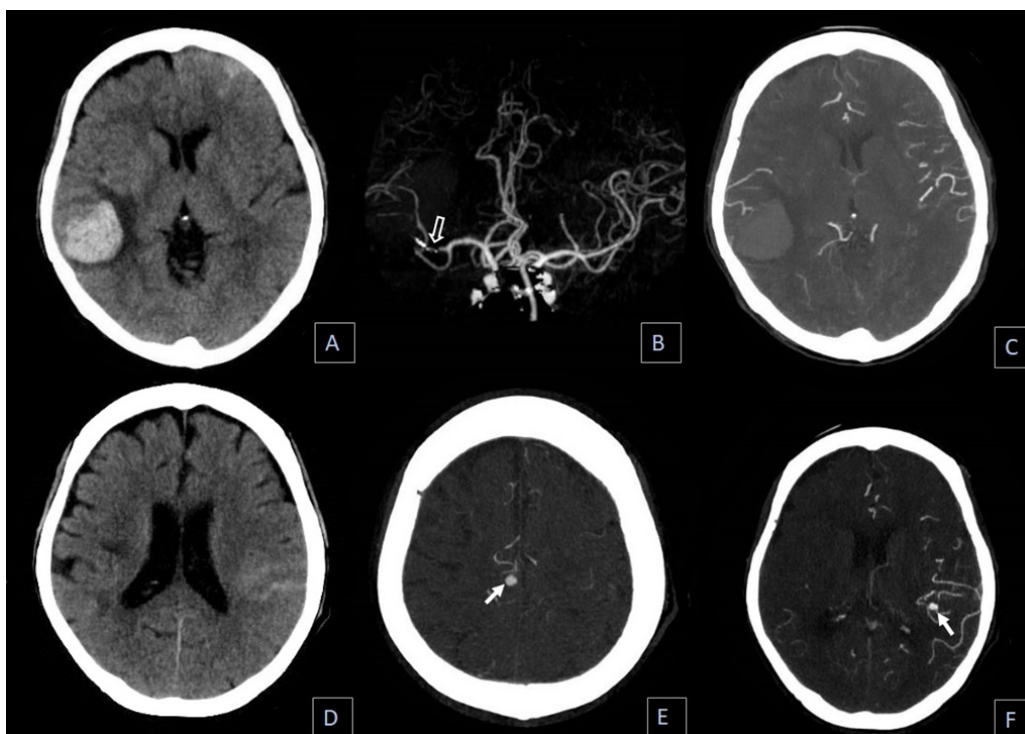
A 51-year-old female underlying SLE and AIHA, post aortic valve replacement, and LV-RA fistula repair, developed candida septicemia and infective endocarditis of the prosthetic heart valve. Axial CT brain (A) reveals acute intraparenchymal hematoma in the right temporal lobe and acute subarachnoid hemorrhage in the left frontal sulci. 3D MIP (B) and axial MIP CT angiography (C) show severe stenosis of the proximal M2 segment of right MCA (open arrow) and no evidence of aneurysm. The follow-up CT 4 days later (D) reveals new acute subarachnoid hemorrhage in the left fronto-parietal sulci and axial MIP CTA (E and F) shows two new aneurysms arising from the cortical branch of the right ACA and the opercular segment of the left MCA (solid arrows).
